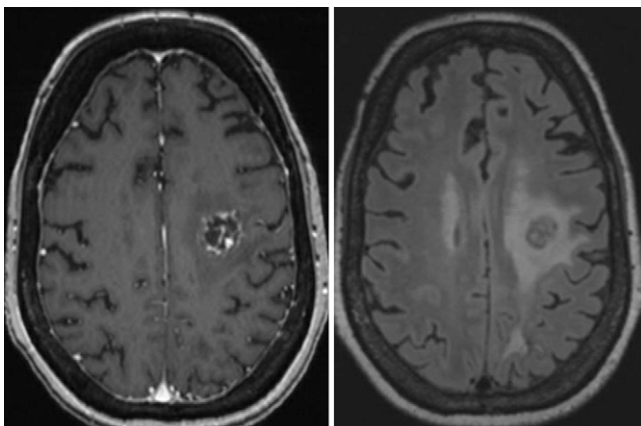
Axial postcontrast T1-weighted (*left*) and fluid-attenuated inversion recovery (FLAIR) (*right*) magnetic resonance images showing the left contralateral glioblastoma that resulted in the patient's eventual demise.
